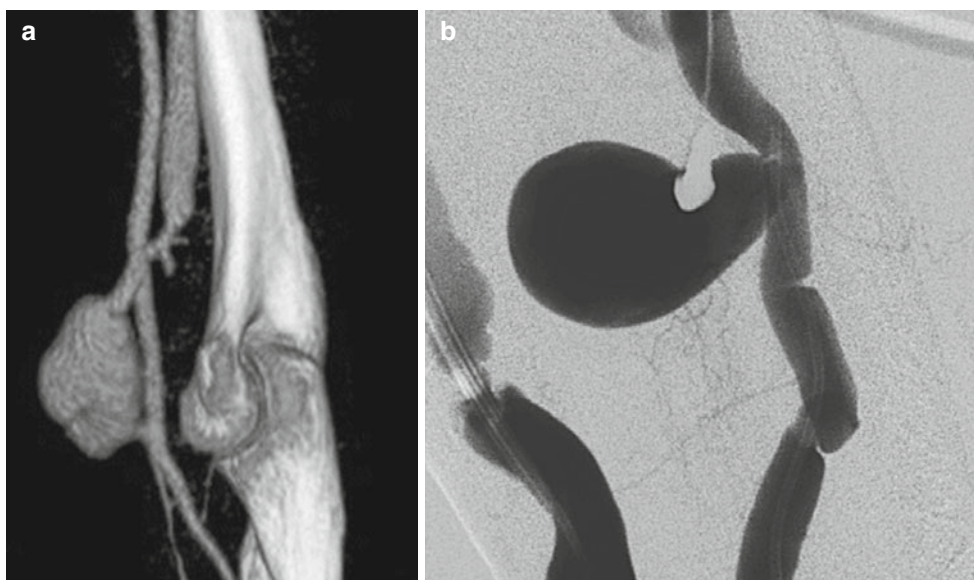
CTA (a) and digital subtraction imaging obtained during a fistulagram (b) showing the presence of a pseudoaneurysm at the radial artery. Patient had undergone a prior balloon angioplasty for a stenosis
